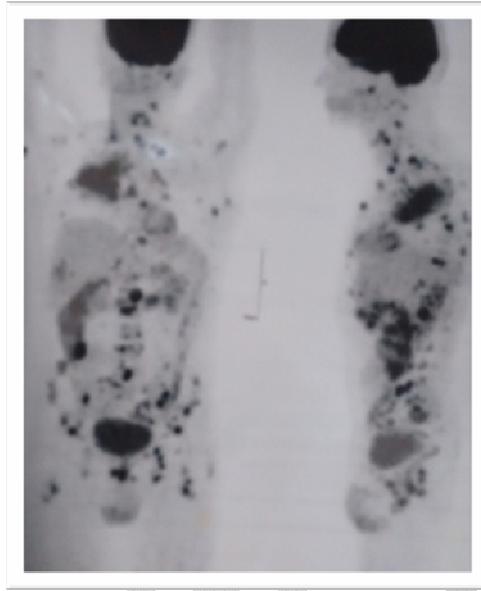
FDG uptake with extensive metastasis to vertebral column, bilateral supraclavicular and mediastinal nodes & other organs like lung, liver and long bones
